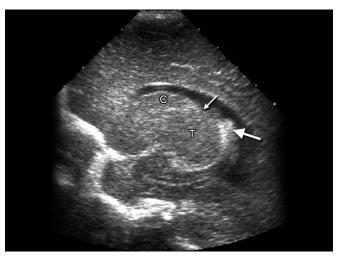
Cranial ultrasound (sagittal view) showing the thalamocaudate groove (thin arrow), the choroid plexus (thick arrow) *Abbreviations*: C, caudate head; T, thalamus.
